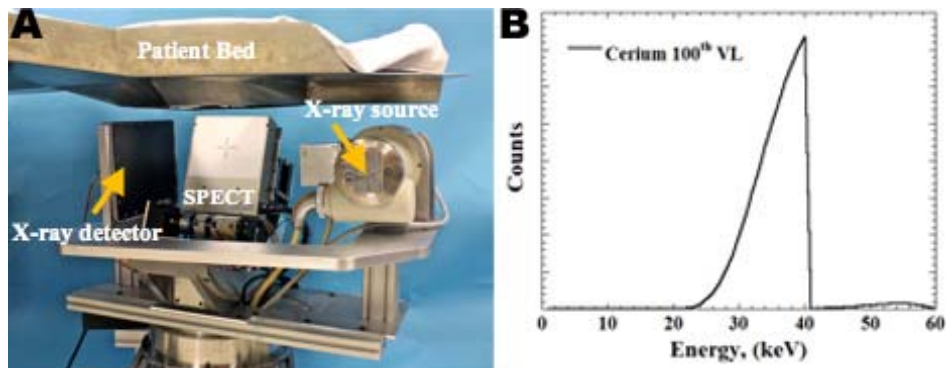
SPECT-CT mammotomography system
